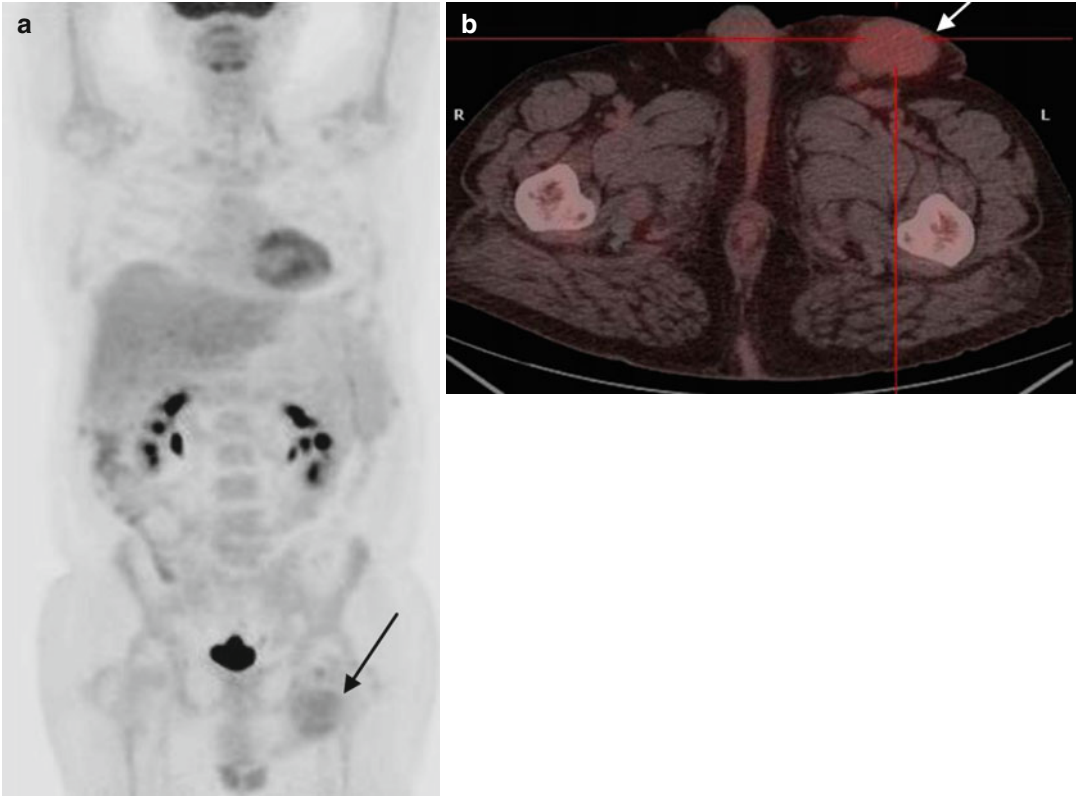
(a, b) MIP-PET and fused PET/CT – end of treatment: Mild FDG uptake (higher than the mediastinum, lower than the liver) at the *left* inguinal mass (*black arrow* in MIP and *white arrow* in the fused images)
